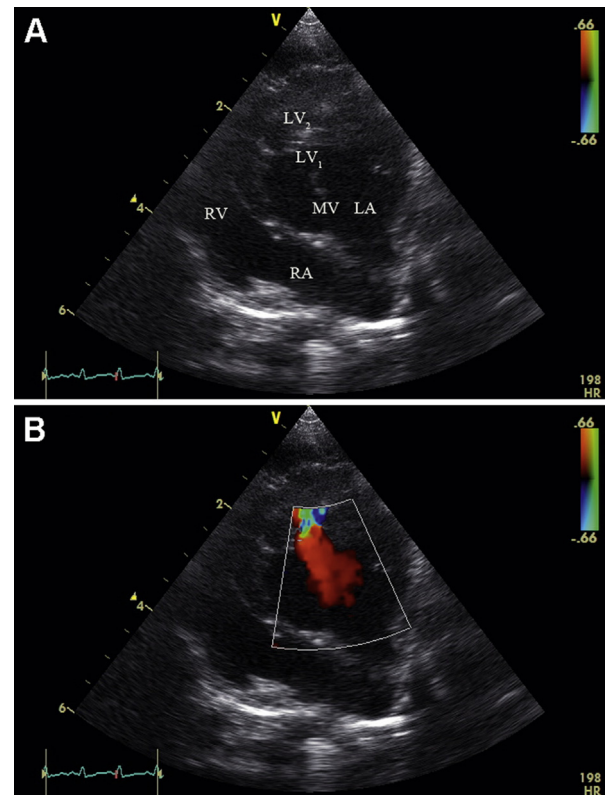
Two-dimensional left apical four-chamber view (A) and left apical four-chamber color flow Doppler echocardiographic image (B), both recorded during late diastole. The color flow Doppler image shows turbulent blood flow passing from the basal portion of the left ventricle (LV₁), across the central perforation of the tissue shelf, into the apical portion of the left ventricle (LV₂). RA, right atrium; RV, right ventricle; LA, left atrium.
